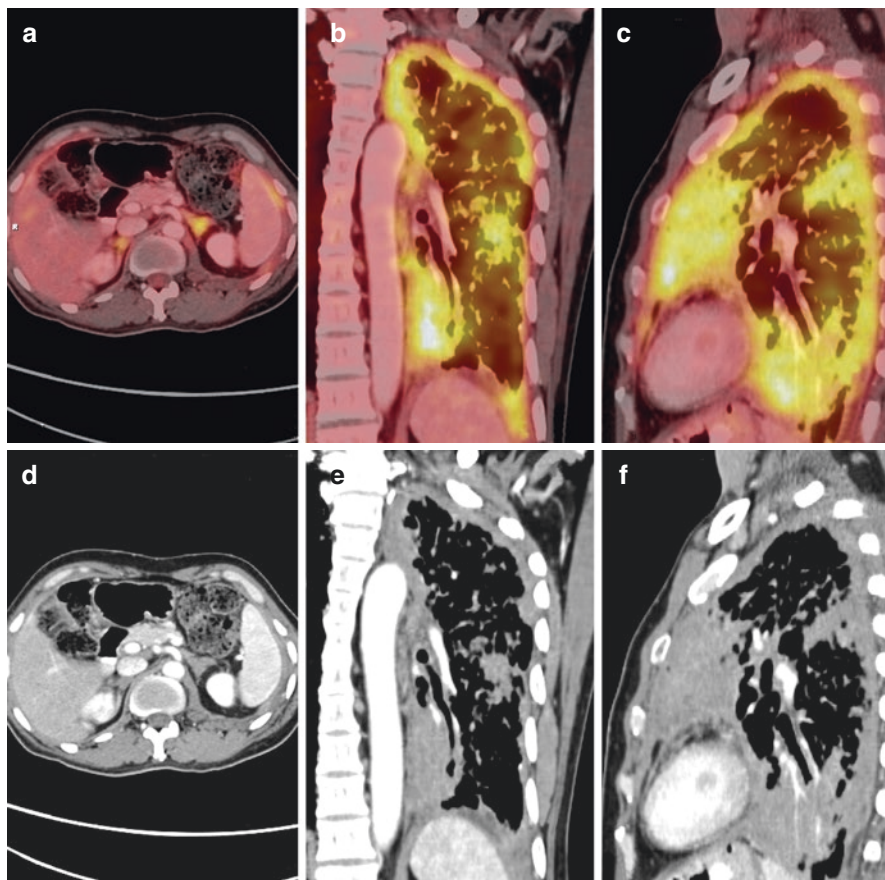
Whole-body PET-CT showing a significant loss of left lung volume with diffuse nodular pleural thickening on left side with significant metabolic activity in PET-CT fused images (a–c) with SUV max of 7.8. Diffuse miliary mottling noted in both lungs also seen in both lungs in CT images (d–f)
